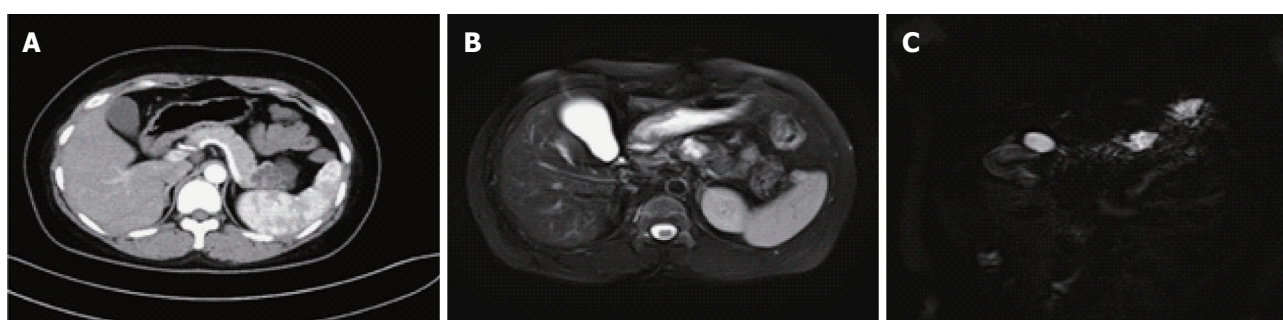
Microcystic pancreatic serous cystic neoplasm presentation on computed tomography/magnetic resonance imaging. A: A microcystic pancreatic SCN lesion was revealed in the tail of the pancreas; B: MRI showed a microcystic lesion in the body of pancreas; C: A microcystic SCN lesion was revealed by magnetic resonance cholangiopancreatography. Images B and C came from the same patient. SCN: Serous cystic neoplasm; MRI: Magnetic resonance imaging.
